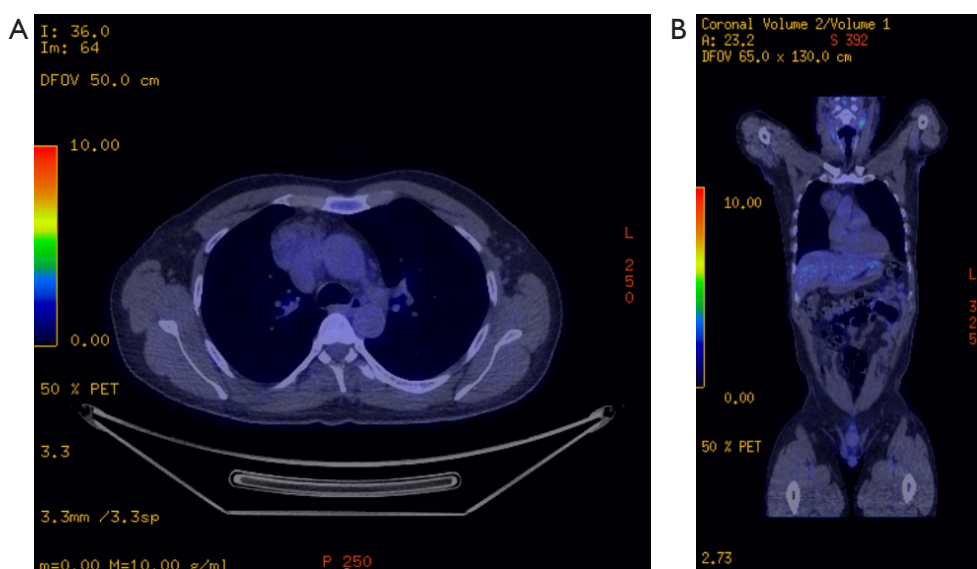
PET CT scan: (A) axial view, (B) coronal view. PET CT, positron emission tomography computed tomography.
